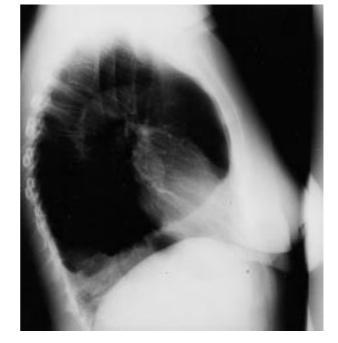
a) Posteroanterior chest radiograph. b) Lateral chest radiograph.
